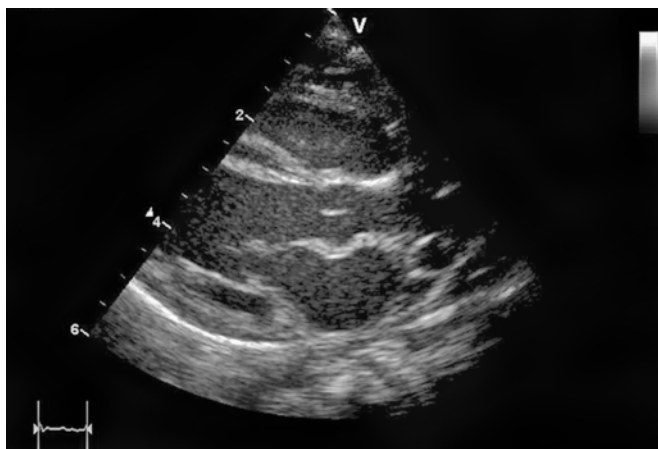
Normal parasternal long-axis echocardiogram
